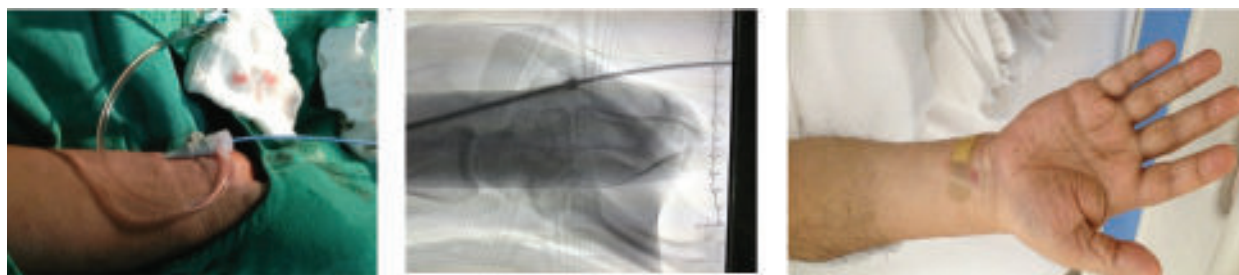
Showing the radiographic images of access site Ulnar approach.
